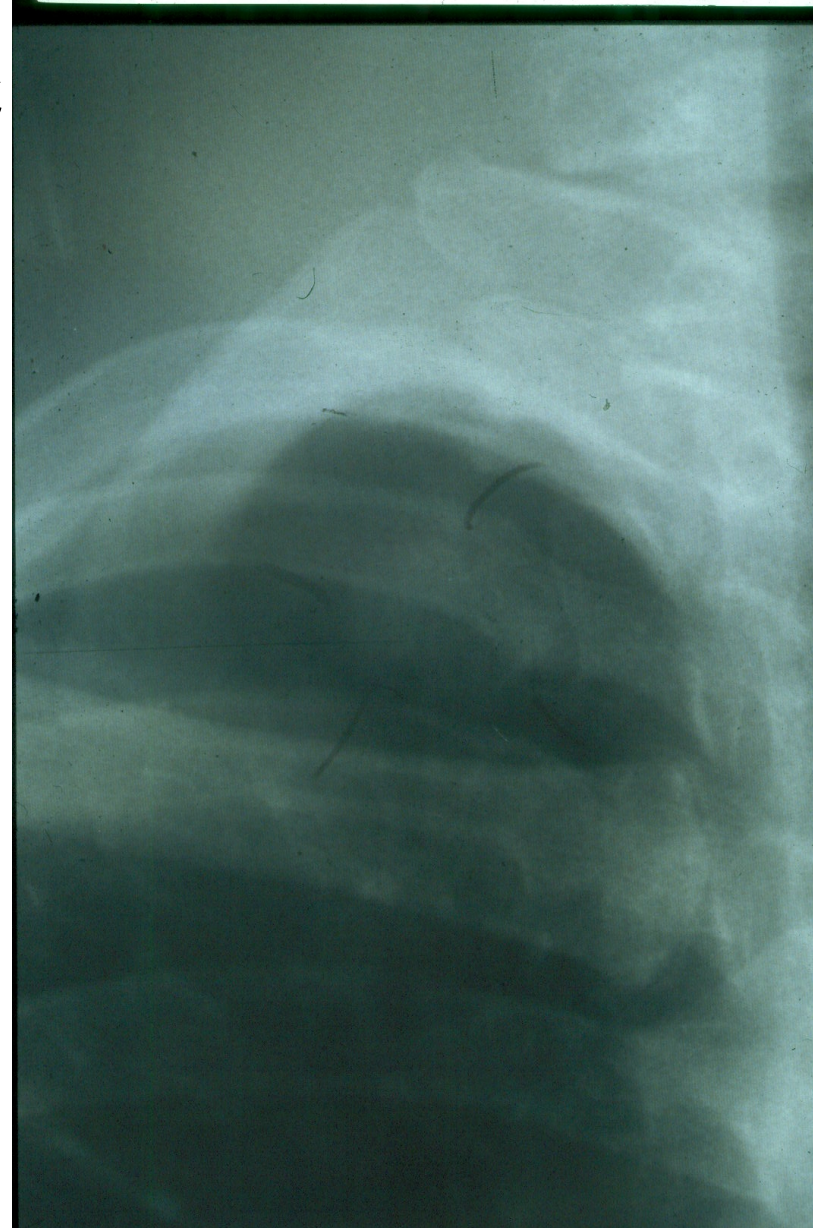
A) and B) PA and Lateral CXR. C) Close up of the right upper lobe (RUL). D) Cross-sectional view of the RUL cavitory lesion on CT.
